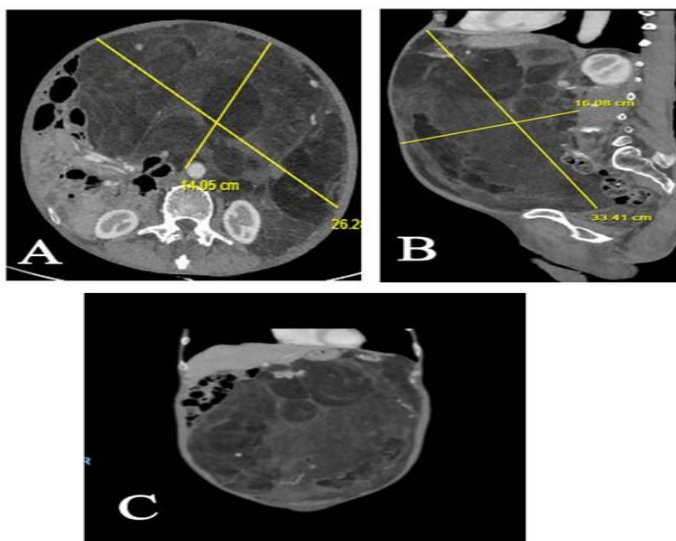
Sagittal section (A), cross section (B) and coronal section (C) of abdominal computed tomography
